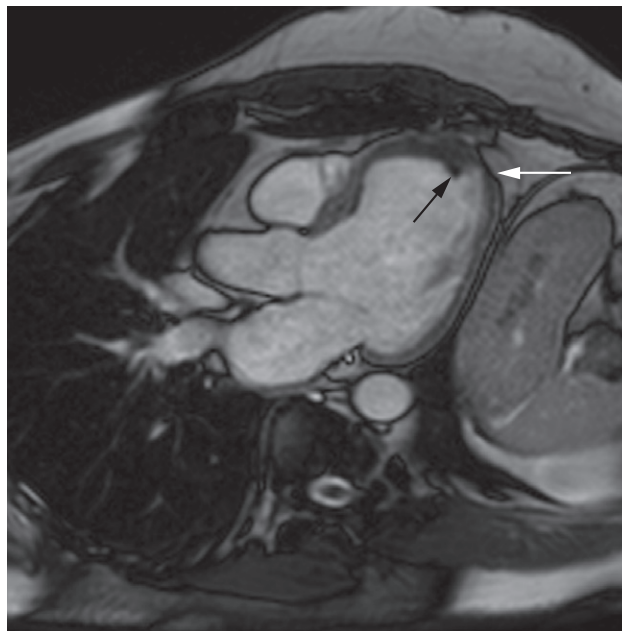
Left ventricular aneurysm due to ischaemic damage. The three-chamber view, T2-weighted image shows a dilated left ventricle with a thin wall, particularly at the apex (white arrows). There is a hypointense intracavitary thrombus (black arrow) due to marked reduction of apical contraction.
